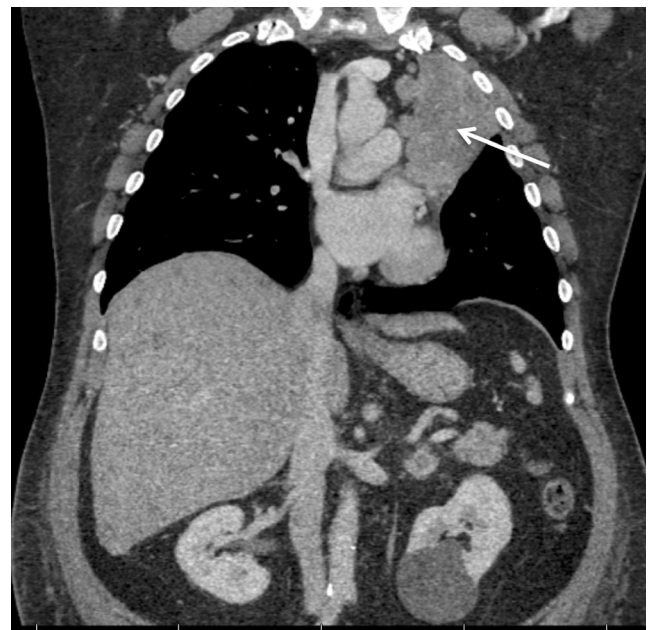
CT of the chest. Coronal view shows a 5.7 × 5.4 cm left hilar mass (arrow) with complete obstruction of the left upper lobe bronchus and left upper lobe collapse.
